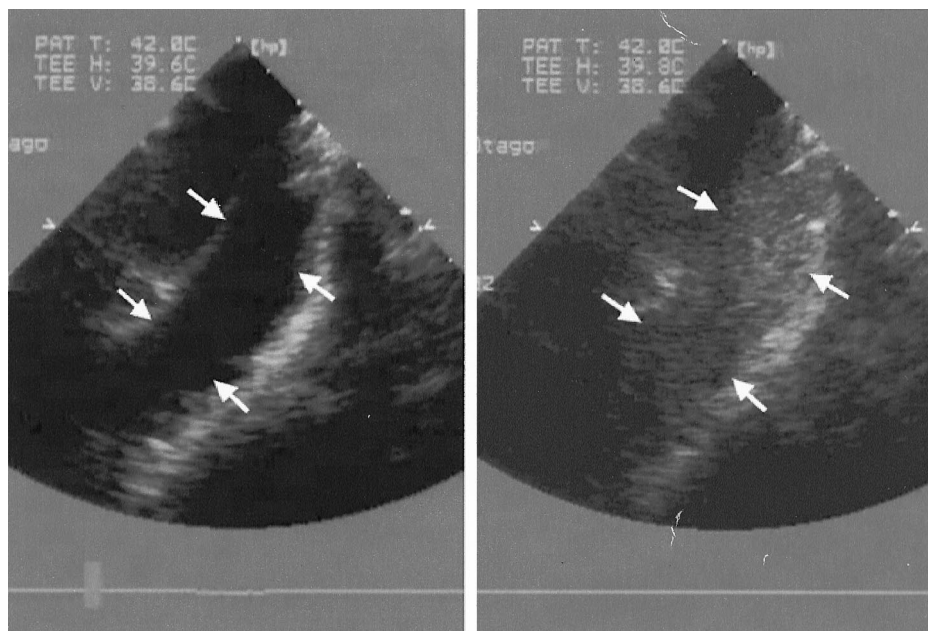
A, Transesophageal echocardiogram showing the main pulmonary artery (arrows) before injection of cement. B, Transesophageal echocardiogram showing the main pulmonary artery (arrows) filled with echogenic material ("snow storm") after injection of cement.
